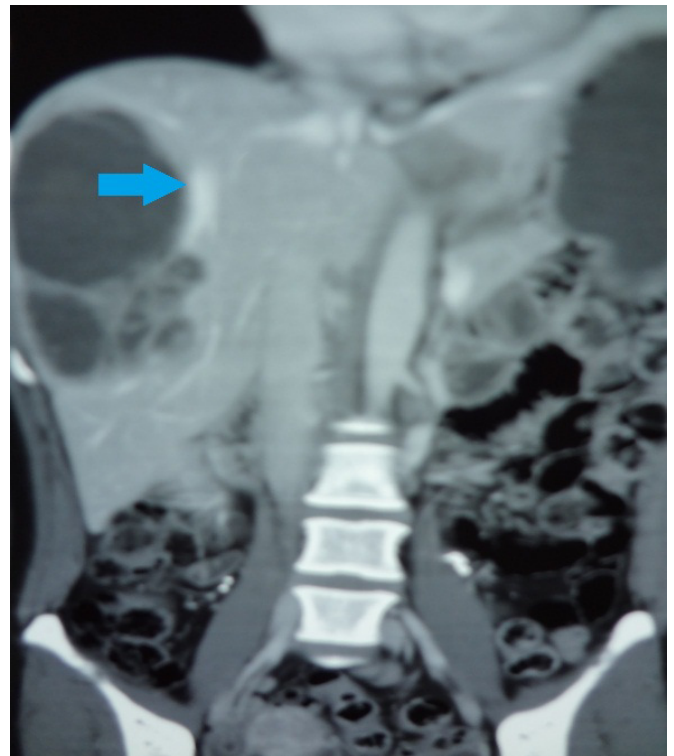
Triphasic CT angiography abdomen showing the tumor mass compressing the right hepatic vein (blue arrow).
